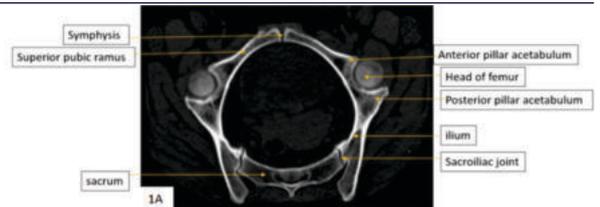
a: CT bone window image showing normal anatomy of the pelvic ring.
